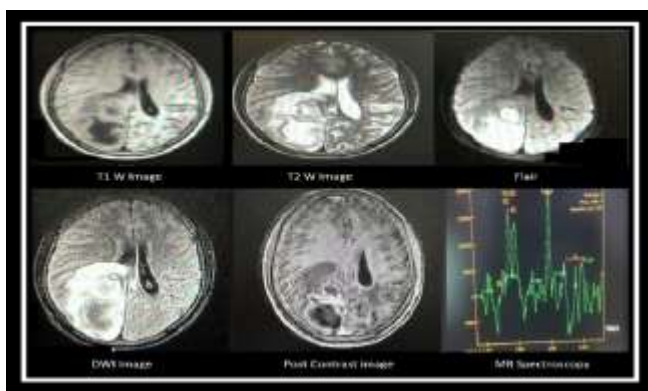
Right Parietal Lobe Lesion on MRI And MRS Favoring Brain Abscess
